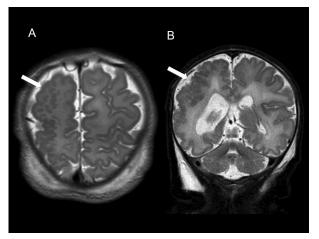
Axial (A) and coronal (B) T2-weighted magnetic resonance imaging of the brain of a term infant who had congenital parvovirus B19 infection demonstrating extensive polymicrogyria on the right.
